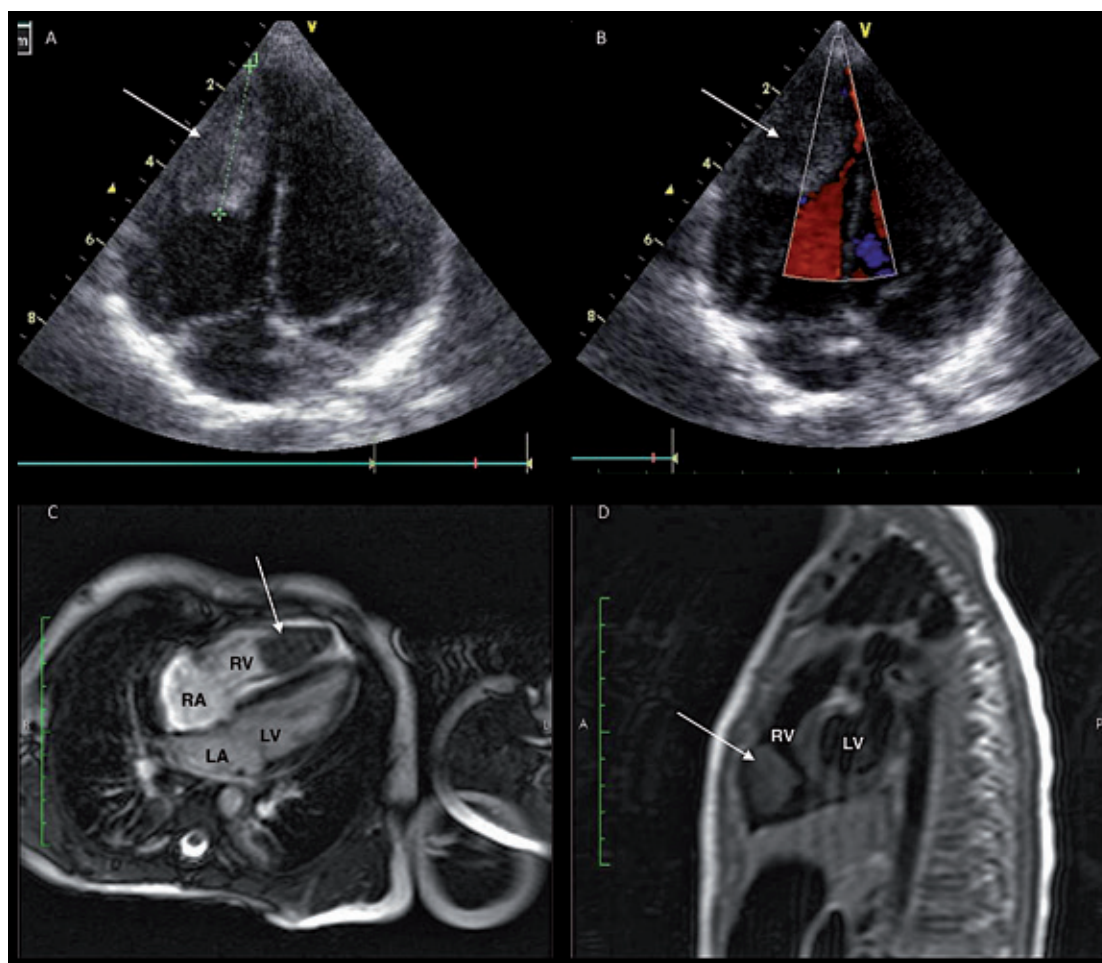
Transthoracic echocardiography of a child at the age of 2 years showing a right ventricular tumor
